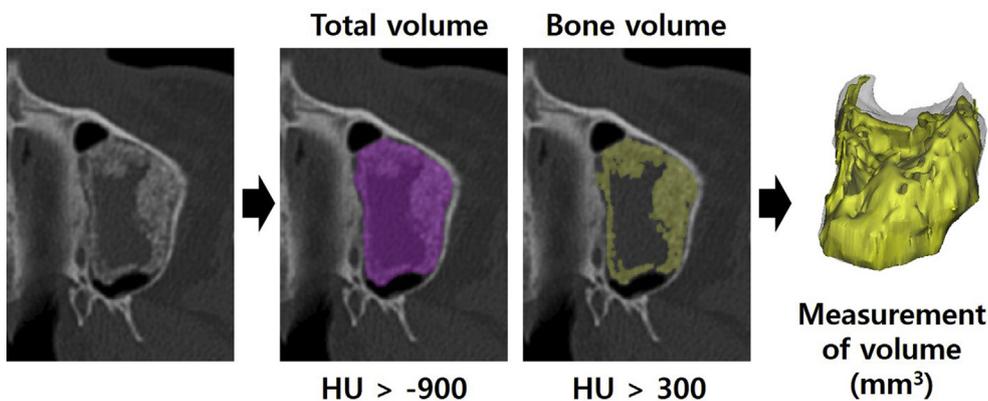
CT analysis method. In each axial plane of the CT, the total area and the bone area in which the MSFA is defined by HU are established, and volumes are calculated by combining them together. Total volume applies to areas below the elevated sinus mucosa in the maxillary sinus with an HU value of -900 or higher. Bone volume applies to areas with an HU value of 300 or more within the space defined by the total volume.
